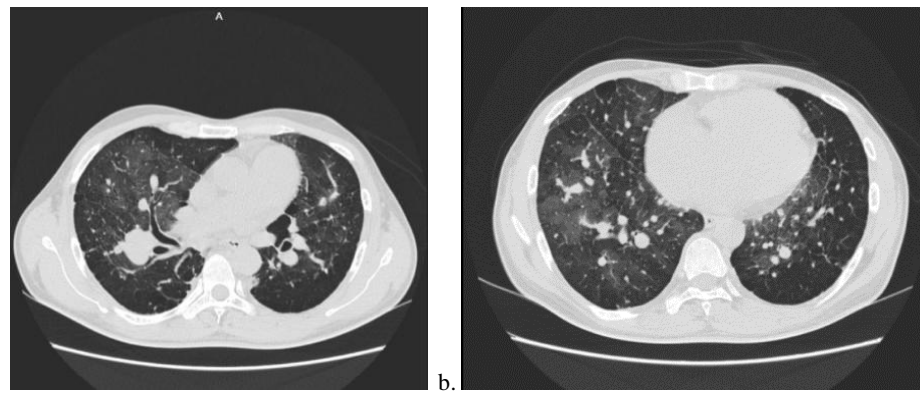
High-resolution computed tomography (HRCT) (a) showed bullae and panlobular emphysema with nodules; (b) revealed ground glass opacity, reticulation, and calcification. Fibrosis was observed in the apex of the lung fields (mosaic pattern), with no significant change from the HRCT in June 2023.
